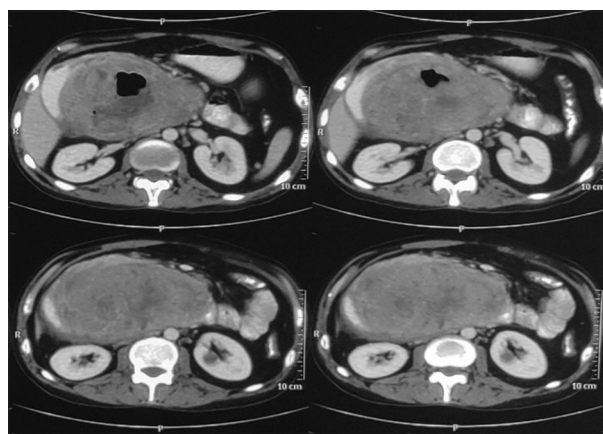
CT scan done in September 2019
